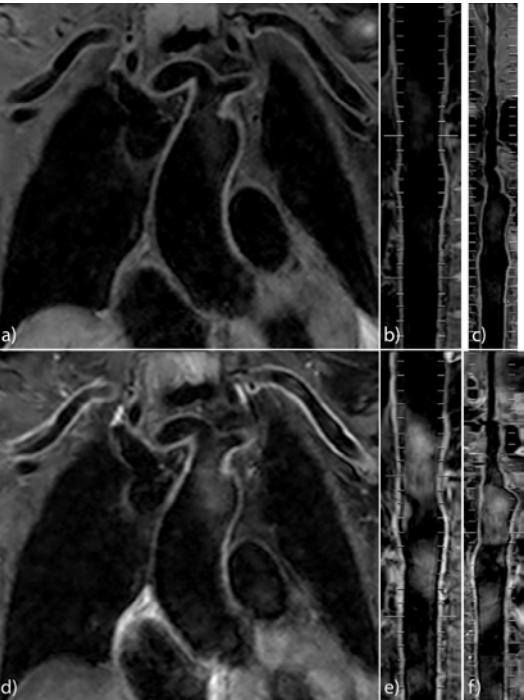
Coronal pre- and post contrast (a, d) VISTA-MRI of the thorax of a 77-yr-old with giant-cell-arteritis and inflammatory activity of the thoracic aorta and both subclavian arteries; orthogonal reconstruction of the aorta pre- and post contrast (b, e); orthogonal reconstruction of the aorta and the left subclavian artery (c) as well as the common and internal carotid artery (f).
